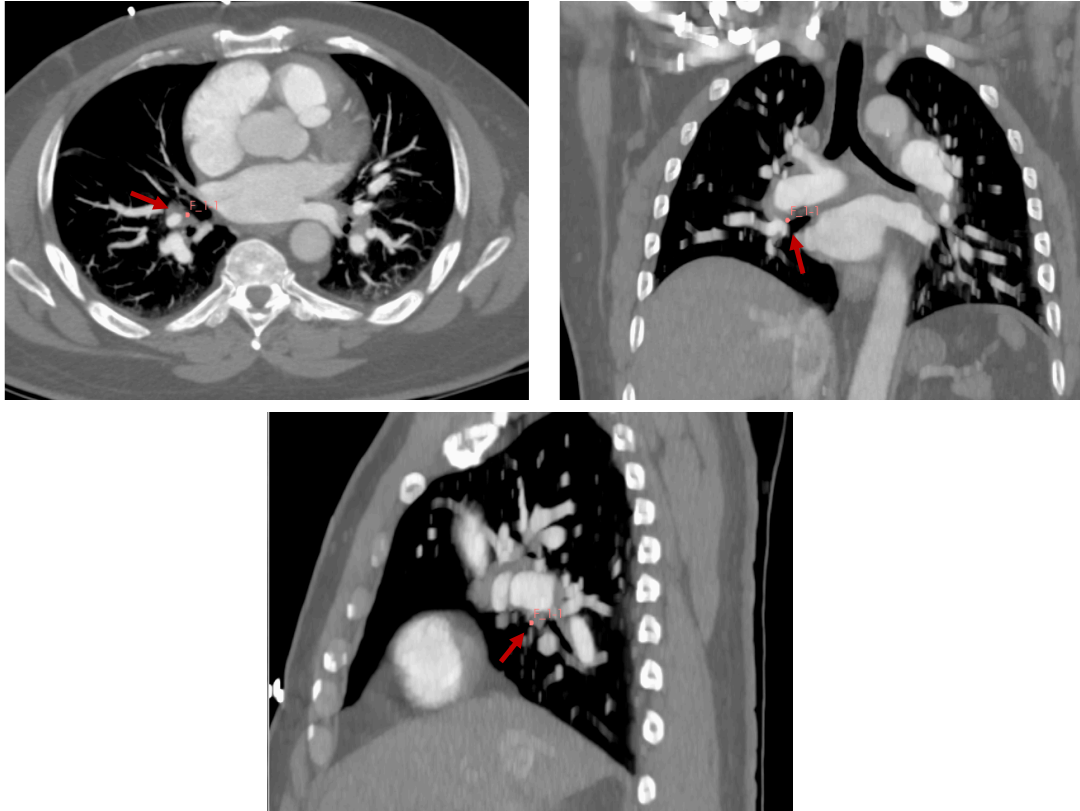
Multiplane view of a CT image from a patient with CTEPH. The red arrow indicates a region of the pulmonary arteries obstructed by a thromboembolism. Data provided by Duke University.
